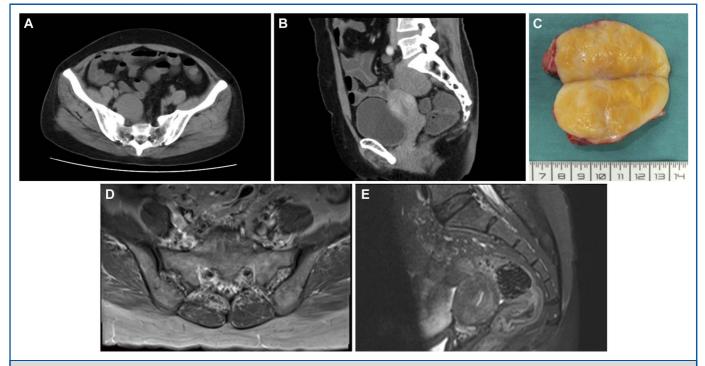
A 50-year-old woman diagnosed with schwannoma (case 1 from Table). A and B, The tumor was classified as type I according to preoperative computed tomography. C, Gross view of the tumor after en bloc resection. D and E, No local recurrence was observed during a 70.9-month follow-up.
